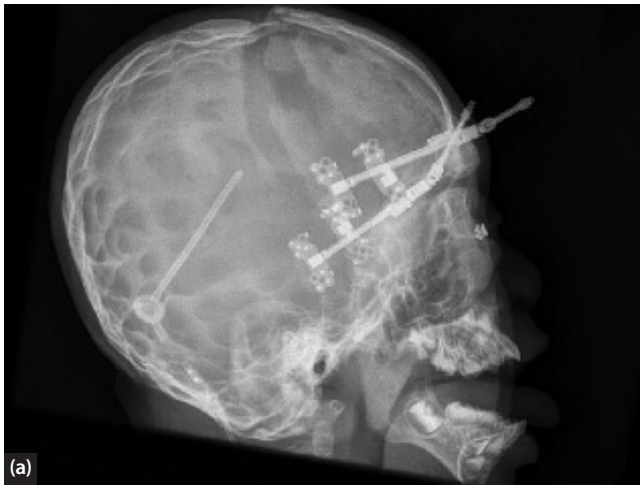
(a) Skull CT of a patient with raised ICP showing ‘copper beating’, treated with a shunt and undergoing distraction osteogenesis of the forehead. (b) Copper beaten bone shows indentation of underlying brain tissue.
